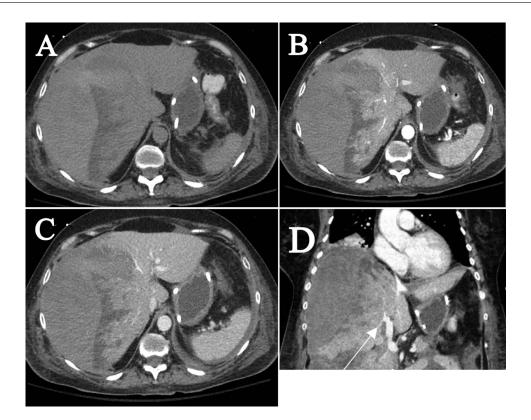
Multiphase CT examination performed 4 days after transfer and 2 days after embolization. Precontrast (A), hepatic arterial (B), and portal venous axial images through the liver (C) demonstrate peripheral-predominant, wedge-shaped hypoattenuating right hepatic regions that do not enhance significantly. Coronal portal venous phase CT image (D) demonstrates the marked mass effect of the perihepatic and subcapsular hematoma resulting in medialization of the liver parenchyma and compression of the right portal vein (arrow).
